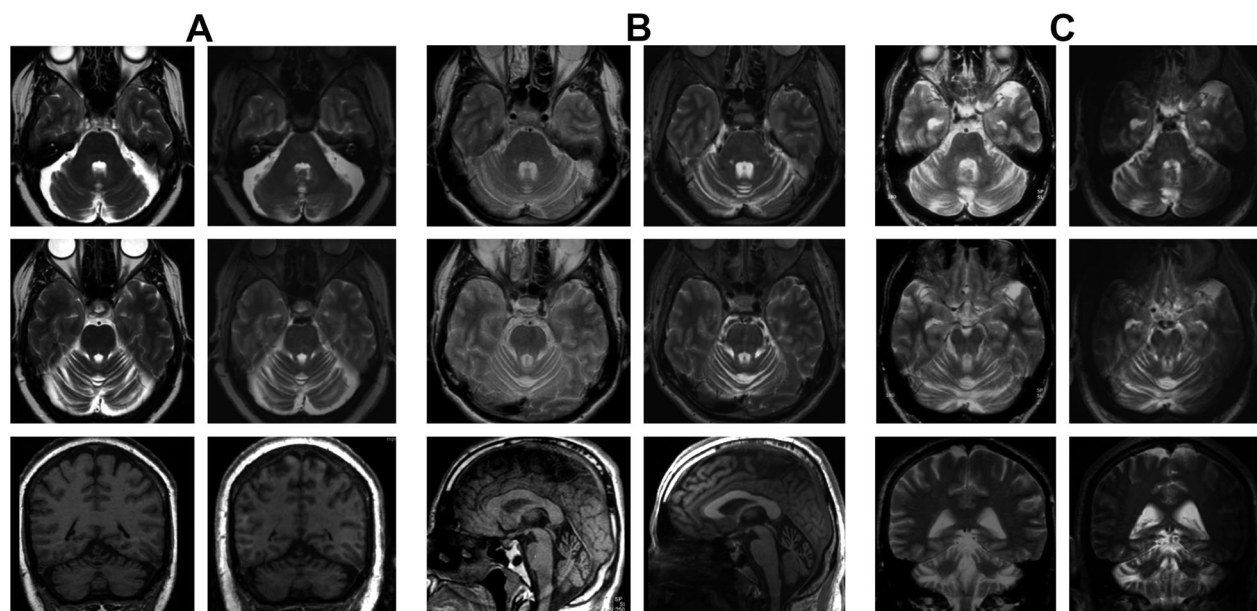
Example of MRI findings, specifically T2 signal of the dentate nuclei, in (A) a healthy subject aged 54 years and (B) a subject with SCA-PRKCG aged 53 years with 23 years since disease onset. As seen in all confirmed SCA-PRKCG of our cohort, there was a peculiar homogeneous T2 hyperintensity of the dentate nucleus (arrow head coronar image) that was not seen in any of the age- and gender-matched control subjects. This hyperintensity had a hypointense correlate in T1-weighted images. Further, as in all SCA-PRKCG, the patient featured cerebellar atrophy most pronounced in upper vermis (arrow sagittal image) and anterior lobe (arrow axial image).
